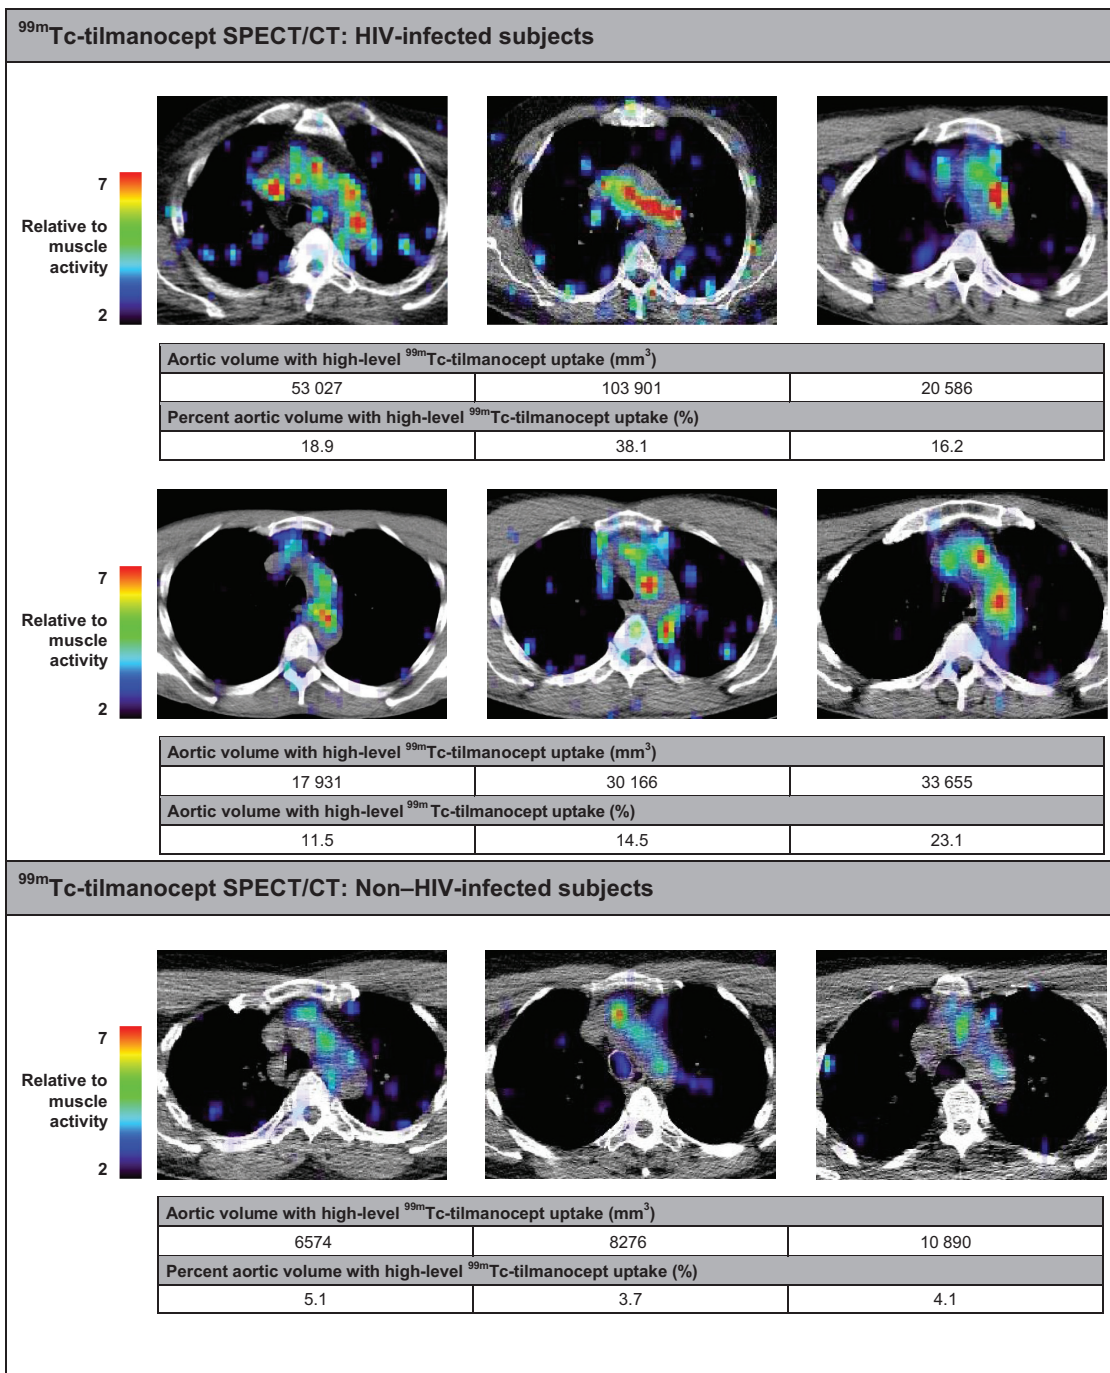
Aortic technetium Tc 99m tilmanocept (^{99m}Tc-tilmanocept) single-photon emission computed tomography (SPECT)/computed tomography (CT) in human immunodeficiency virus (HIV)-infected and non-HIV-infected subjects. Axial cross-sections of the aorta from ^{99m}Tc-tilmanocept SPECT/CT scans are shown for HIV-infected (n = 6) and non-HIV-infected (n = 3) subjects. Aortic volume and the percentage of aortic volume with high-level ^{99m}Tc-tilmanocept uptake (>5 times muscle ^{99m}Tc-tilmanocept uptake) are displayed for each subject. The adjacent color scale indicates aortic ^{99m}Tc-tilmanocept uptake relative to muscle ^{99m}Tc-tilmanocept uptake, with red representing areas of high relative ^{99m}Tc-tilmanocept uptake. Abbreviation: ^{99m}Tc, metastable technetium isotope.
